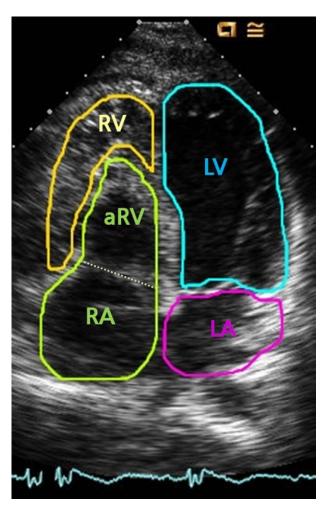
Measurement of the severity of Ebstein anomaly. Planimetry was performed in the apical 4-chamber view at end diastole. In this case, the ratio of the combined area of the right atrium (RA) and atrialized right ventricle (aRV) divided by the combined area of the functional RV proper, left atrium (LA), and left ventricle (LV) was 0.82, which falls under severity grade 2.
